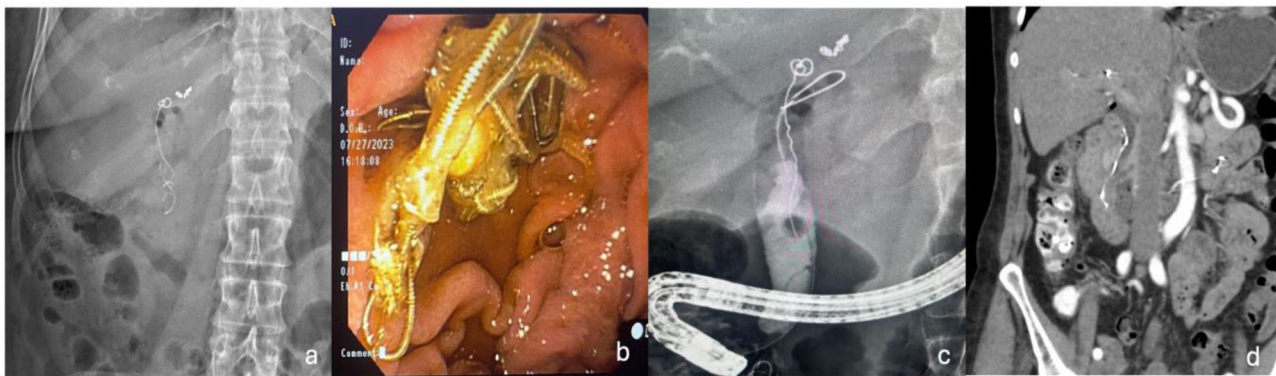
(a) Preliminary x-ray showing the partial migration of the embolization material into the bile duct and duodenum. (b) Endoscopic evidence of the vascular embolization metallic material in the duodenum. (c) Cholangiographic image of the gallstone associated with the material that migrated into the bile duct. (d) CT angiography ruling out flow to the level of the pseudoaneurysm after the partial migration of the material into the bile duct and up to the fourth part of the duodenum.
